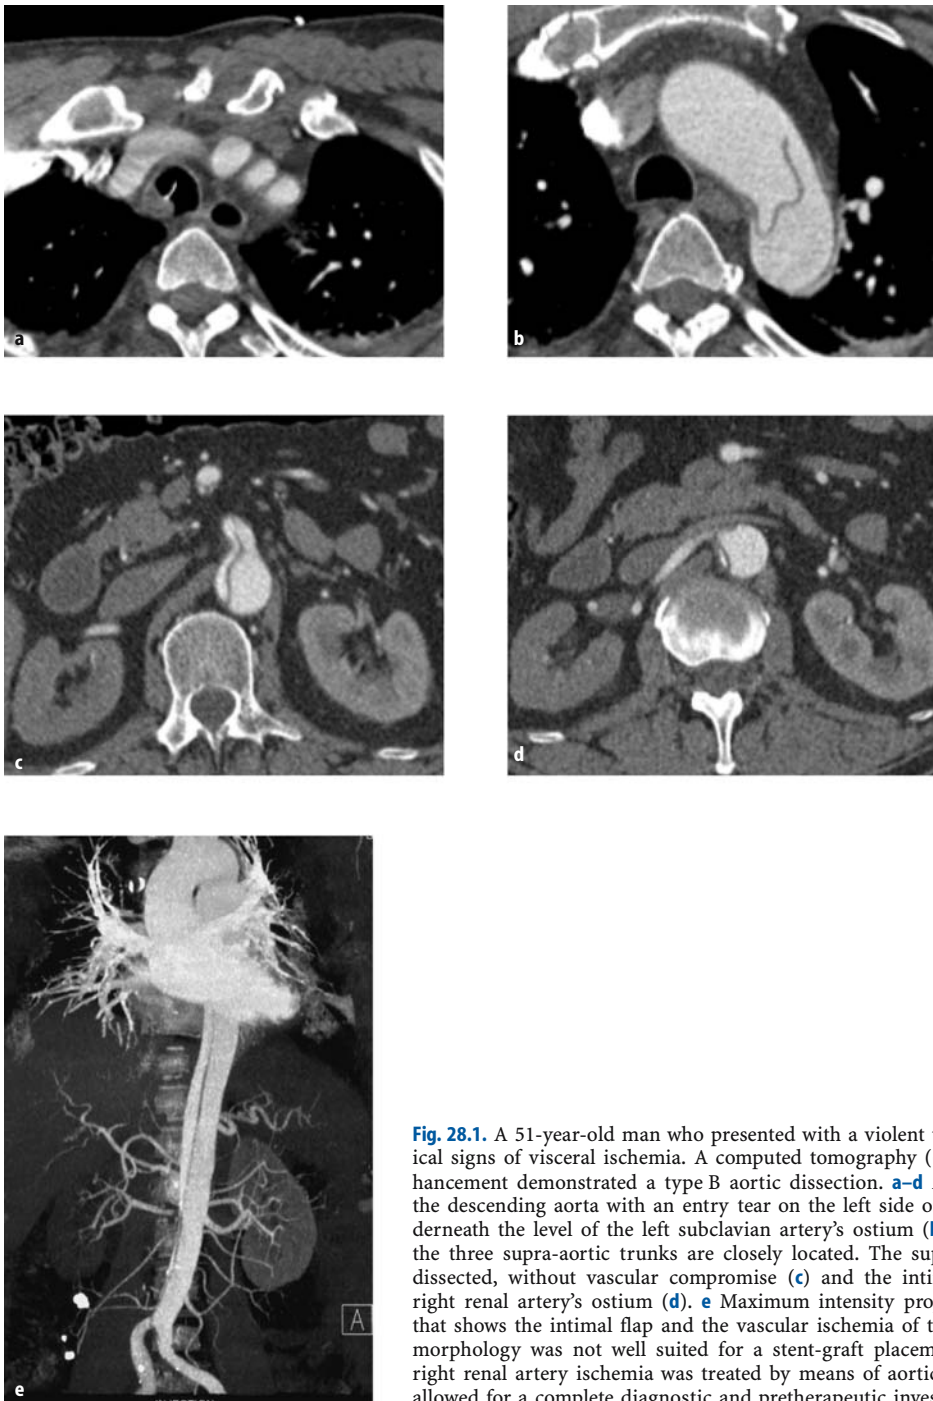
A 51-year-old man who presented with a violent thoracic pain, without clinical signs of visceral ischemia. A computed tomography (CT) scan after contrast enhancement demonstrated a type B aortic dissection. a–d Axial images: dissection of the descending aorta with an entry tear on the left side of the thoracic arch (a), underneath the level of the left subclavian artery's ostium (b). Note that the origins of the three supra-aortic trunks are closely located. The superior mesenteric artery is dissected, without vascular compromise (c) and the intimal flap is pinned on the right renal artery's ostium (d). e Maximum intensity projection (MIP), frontal view that shows the intimal flap and the vascular ischemia of the right kidney. The aortic morphology was not well suited for a stent-graft placement and thus the dynamic right renal artery ischemia was treated by means of aortic fenestration. The CT scan allowed for a complete diagnostic and pretherapeutic investigation of the disease
